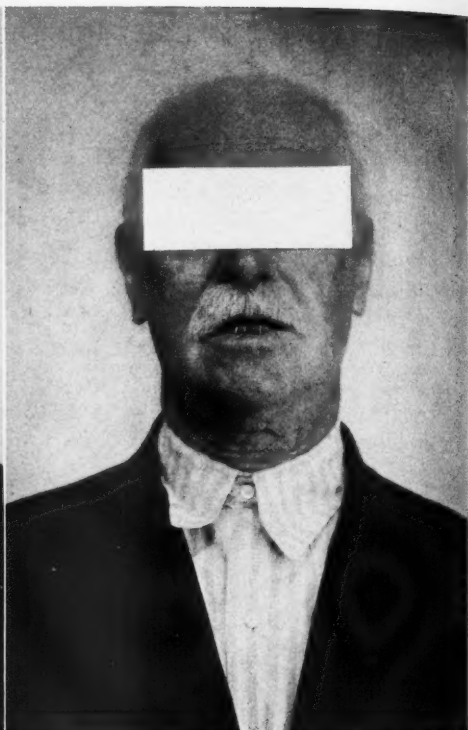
Same case. Condition of the lip one year after X-ray treatment. There has been no evidence of recurrence after nine years.
